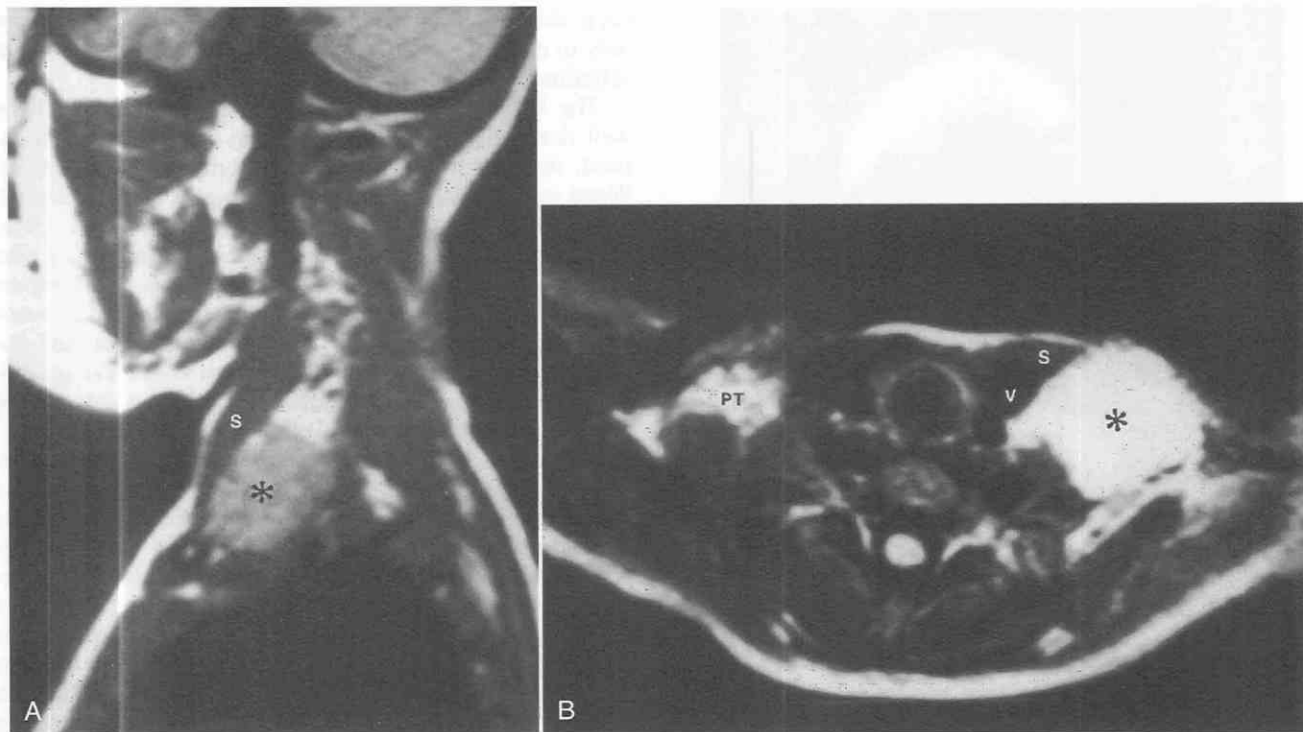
Cystic hygroma. A, Sagittal T1-weighted MR image demonstrates a lobulated posterior triangle mass (*asterisk*) that is moderately hyperintense to muscle and located deep to the posterior margin of the sternocleidomastoid muscle (s). Note how the hygroma tracks posterior to the internal jugular vein (V). B, The hygroma appears virtually isointense to fat in the right posterior triangle (PT), owing to window width and level.
